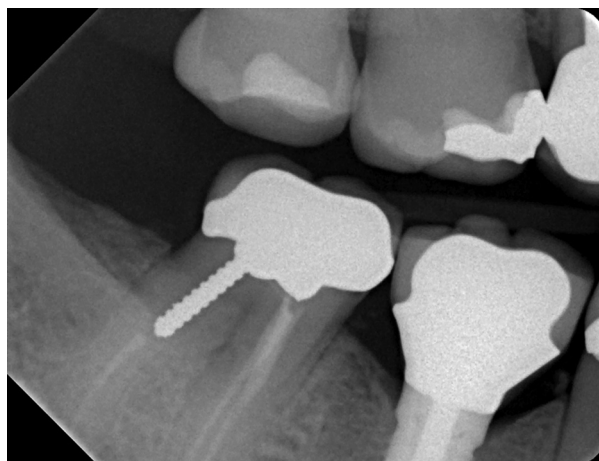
Radiograph showing open contact that developed approximately 1 year after restoration insertion (November 2, 2011) on the mesial aspect of the implant restoration at site no. 30. No interdental pathosis was present.
